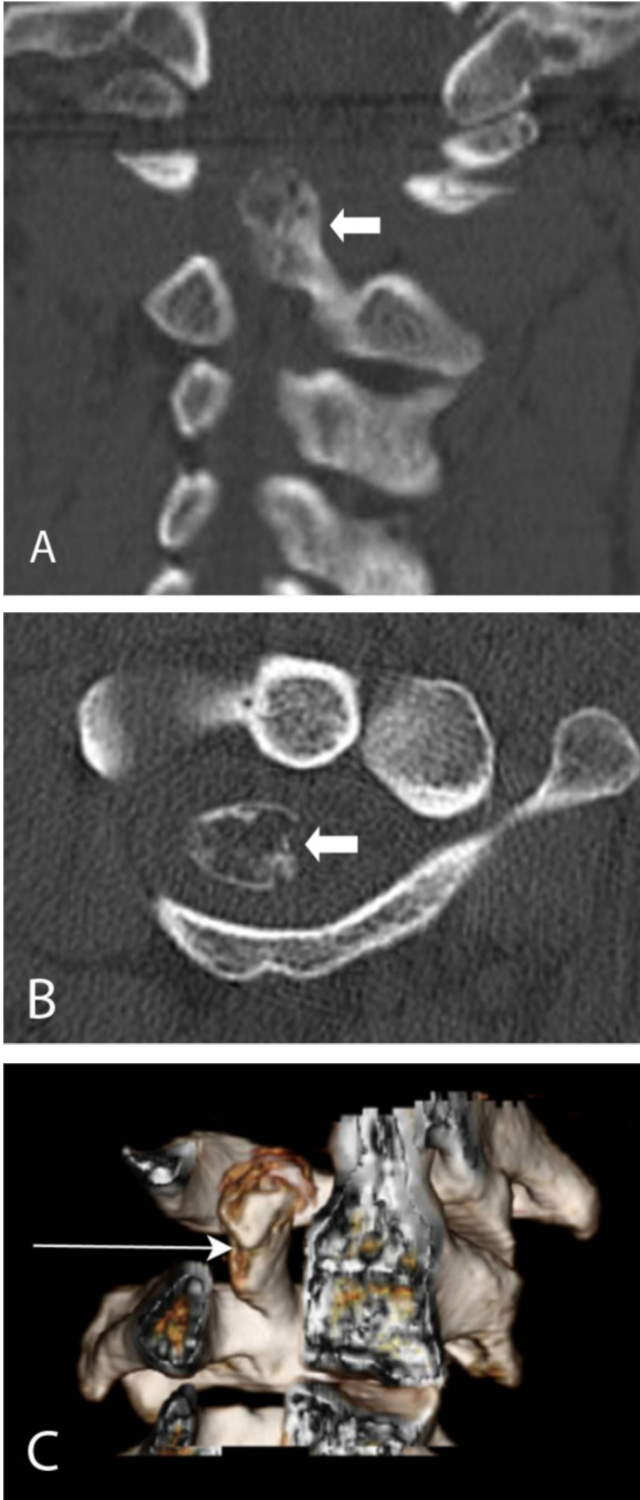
Coronal (A) and axial (B) CT images of the cervical spine demonstrate osteochondroma (arrow) arising from the left C2 lamina and projecting into the spinal canal. 3D reconstructed image (C) demonstrates the osseous outgrowth projecting superiorly towards the dens (arrow).
